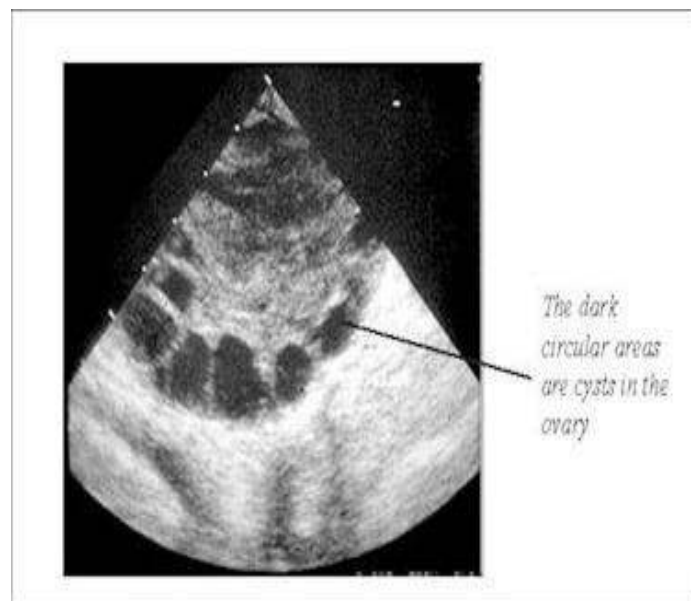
Ultrasound scan photo
